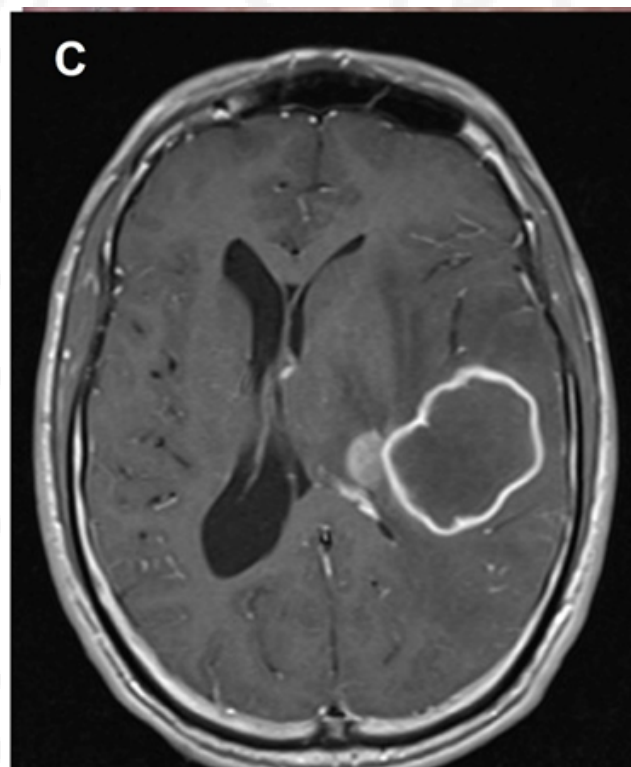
C) T1-weighted brain MRI showing a large contrast enhancing lesion with mass effect in the left hemisphere.
